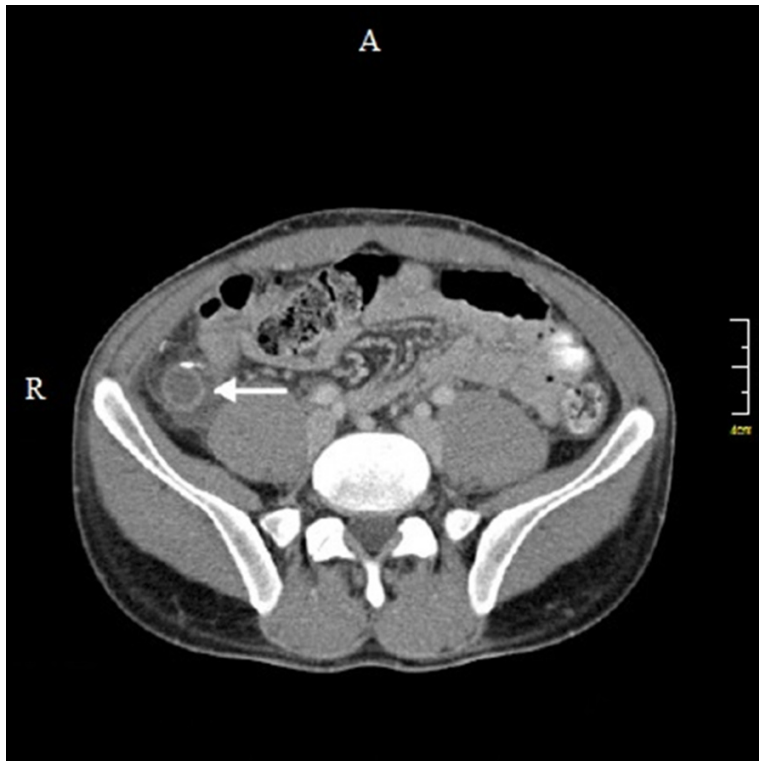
Abdominal CT scan in patients with acute appendicitis (white pointer).
